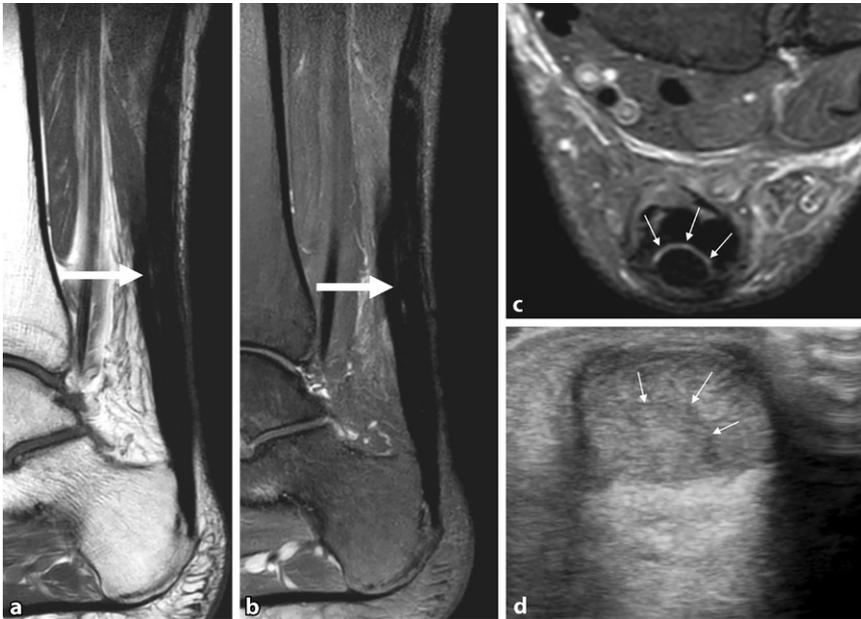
▲ MRI at 4 months post-surgery shows a homogeneous tendon in the former rupture zone appearing as a nearly normal finding in the T1-weighted (a) and STIR (b) sequences in the sagittal plane displaying an intense linear image (*thick arrow*). The latter is easier delineated in the axial plane (c) with STIR sequences (*thin arrows*). This finding is very well visualized with US (d)
